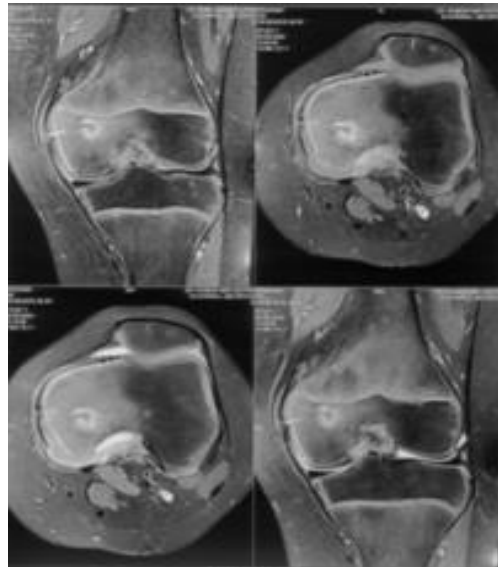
Axial and coronal MRI images showing medial femoral condyle lesion adjacent to physis with a central sclerotic area.
